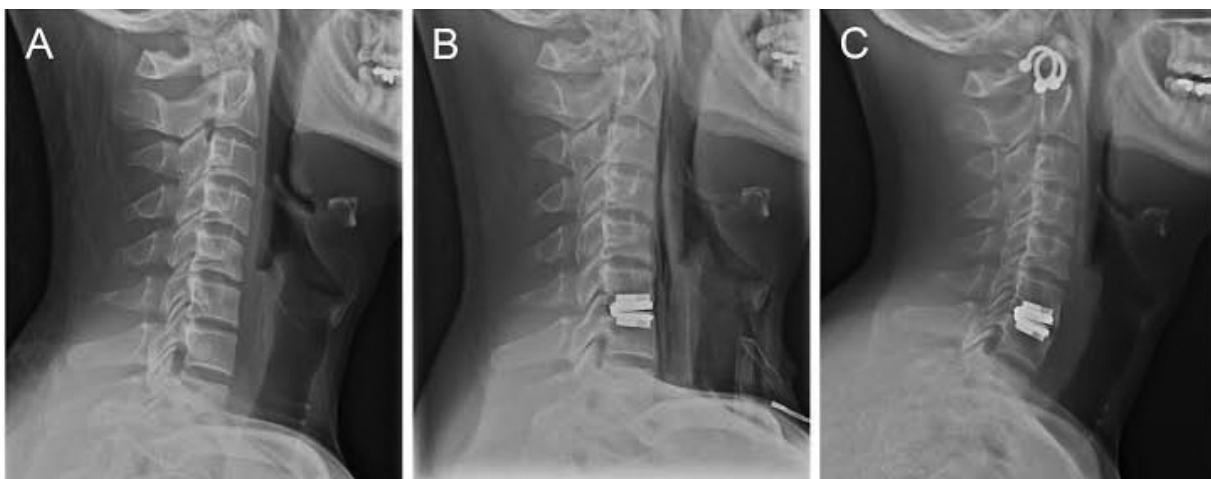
Delayed fusion post ProDisc-C insertion: a) Pre-operative neutral lateral radiograph, b) immediate post-operative neutral lateral radiography and c) late post-operative neutral lateral radiograph demonstrating bridging anterior osteophytes (with loss of motion).
